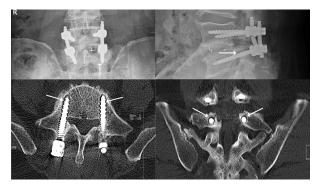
Postoperative follow-up radiographs and CT scans shows screw loosening.
